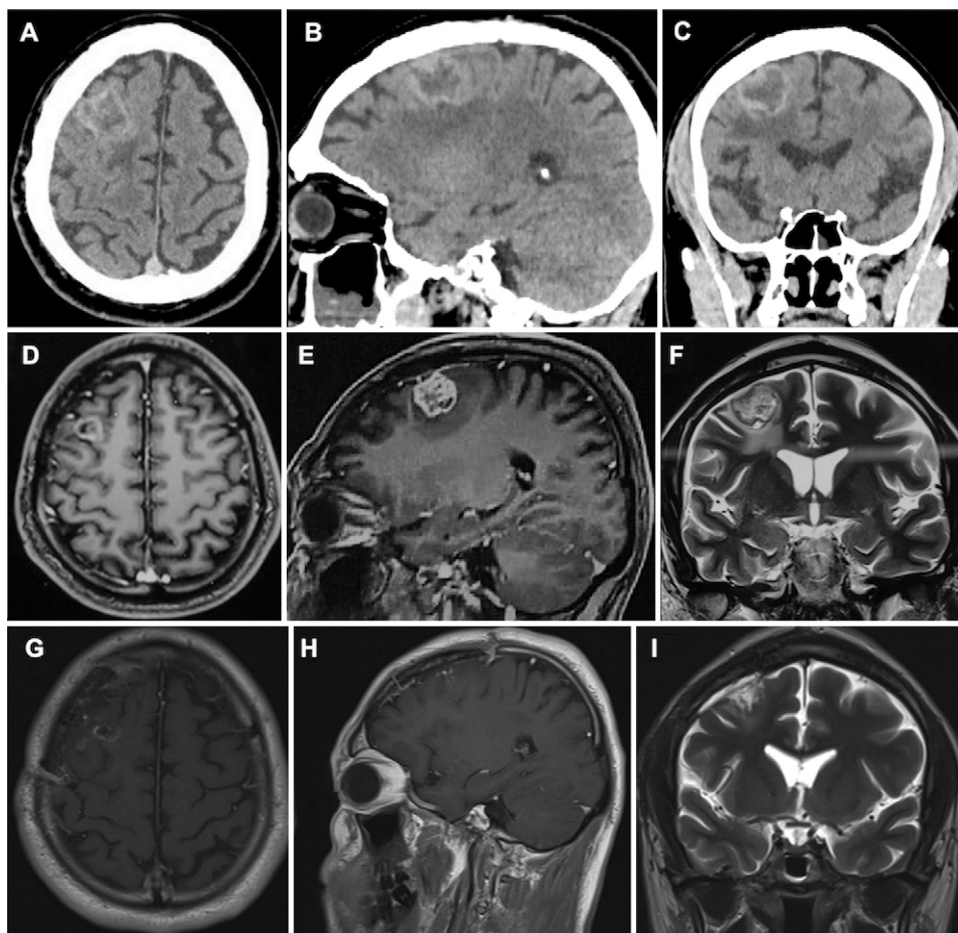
Preoperative axial (A), sagittal (B), and coronal (C) head CT scans without contrast depict a heterogeneous and irregular lesion of the hypodense core and hyperdense periphery in the right frontal lobe. No midline deviation was present. Preoperative axial (D) and sagittal (E) MRI with gadolinium revealed a ring-enhancing lesion with a necrotic center and neoformative appearance of $25 \times 35 \times 23$ mm in the cortical area of the frontal lobe. Preoperative coronal fluid-attenuated inversion recovery (FLAIR) sequence (F) depicts a heterogeneous and hyperintense lesion in the cortical frontal area. Postoperative T1-weighted (G and H) and FLAIR (I) sequences demonstrated complete tumor excision.
